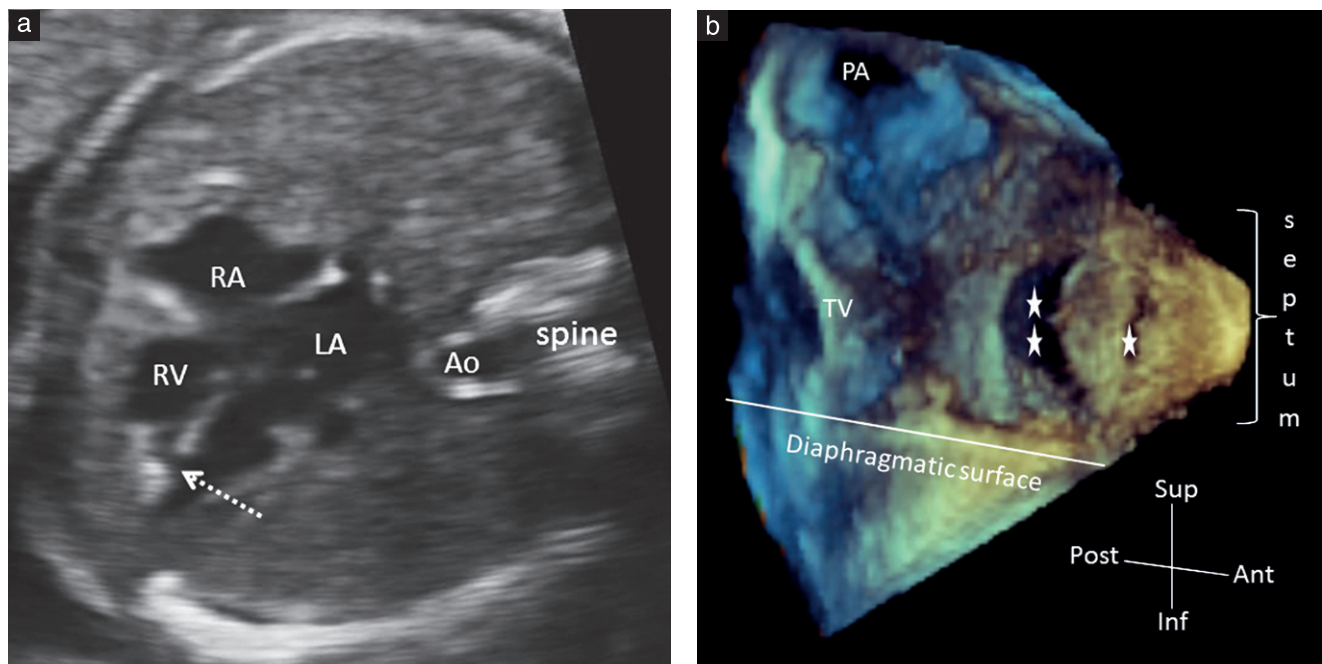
Prenatal (a) and postnatal (b) echocardiograms in a case thought to have a small ventricular septal defect (VSD) prenatally, which had to be closed during infancy due to a large left-to-right shunt. (a) Prenatal two-dimensional echocardiogram at 20 weeks' gestation showing a single small trabecular muscular VSD (arrow). (b) Postnatal three-dimensional transthoracic echocardiogram of the defect rendered in an 'anatomic' orientation to demonstrate the interventricular communication. This view from the right ventricle demonstrates a large () muscular VSD and an additional (*) more apical muscular VSD. In the four-chamber view, the minor axis of such 'slit-like' defects is visualized, which underestimates the true extent of the defect. Ant, anterior; Ao, aorta; Inf, inferior; LA, left atrium; PA, pulmonary artery; Post, posterior; RA, right atrium; RV, right ventricle; Sup, superior; TV, tricuspid valve.
